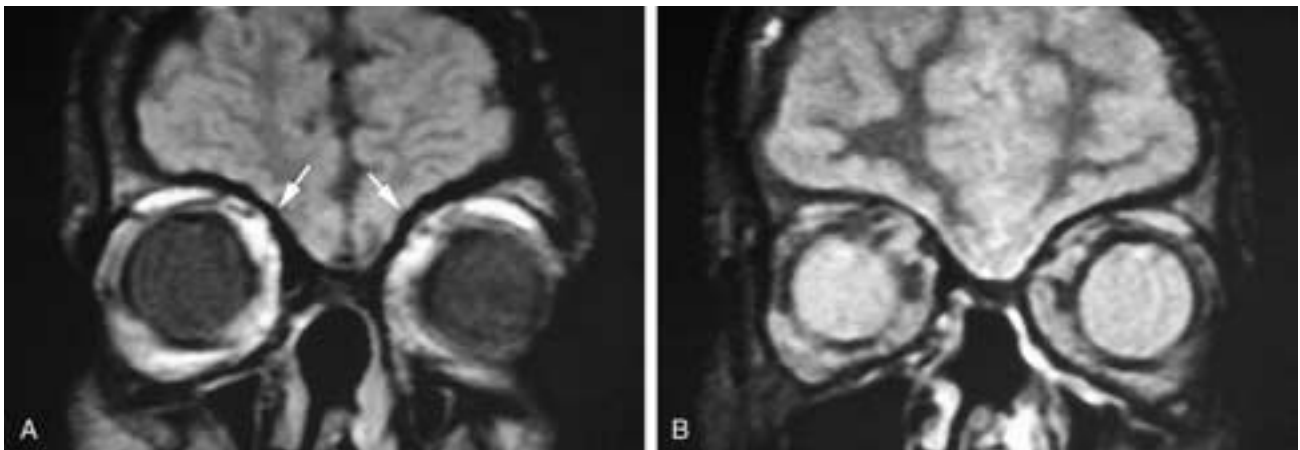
Coronal T1-weighted (A) and proton density (B) MR images on a patient who has had a craniofacial resection. The graft has fibrosed, giving it signal void on all sequences. Because the graft has about the same thickness as the adjacent bone (*arrows* in A) in the remaining floor of the anterior cranial fossa, no obvious defect is seen. The imaging key to identifying that this surgery was performed is the absent normal contour of the crista galli and fovea ethmoidalis. Note that the cranial and sinonasal margins of the graft site are smooth.
